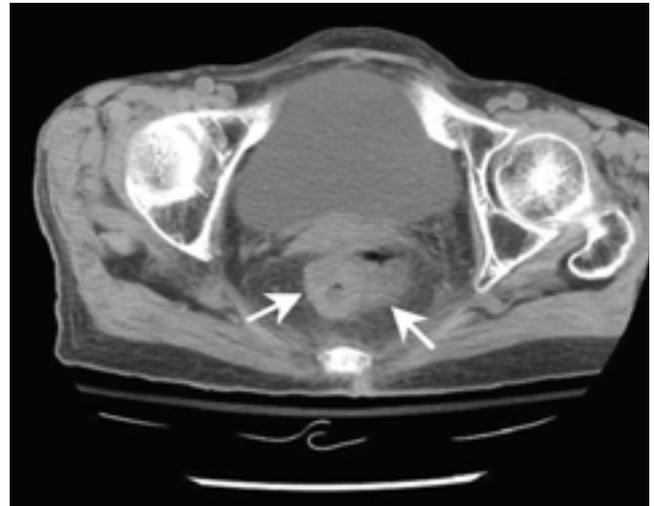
Abdominal CT shows concentric wall thickening of the rectum with perirectal fat infiltration (arrows).
